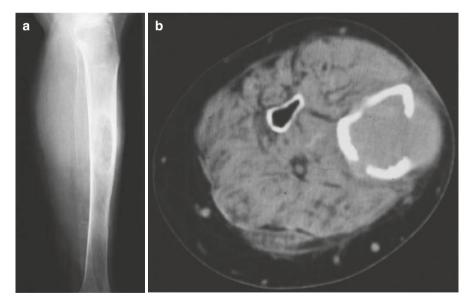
Example of brown tumor associated with hyperparathyroidism (Reprinted with permission from Springer [5]) (a) Osteolytic lesion on X-ray examination of tibia, (b) Osteolytic lesion on transverse section of tibia on CT scan
